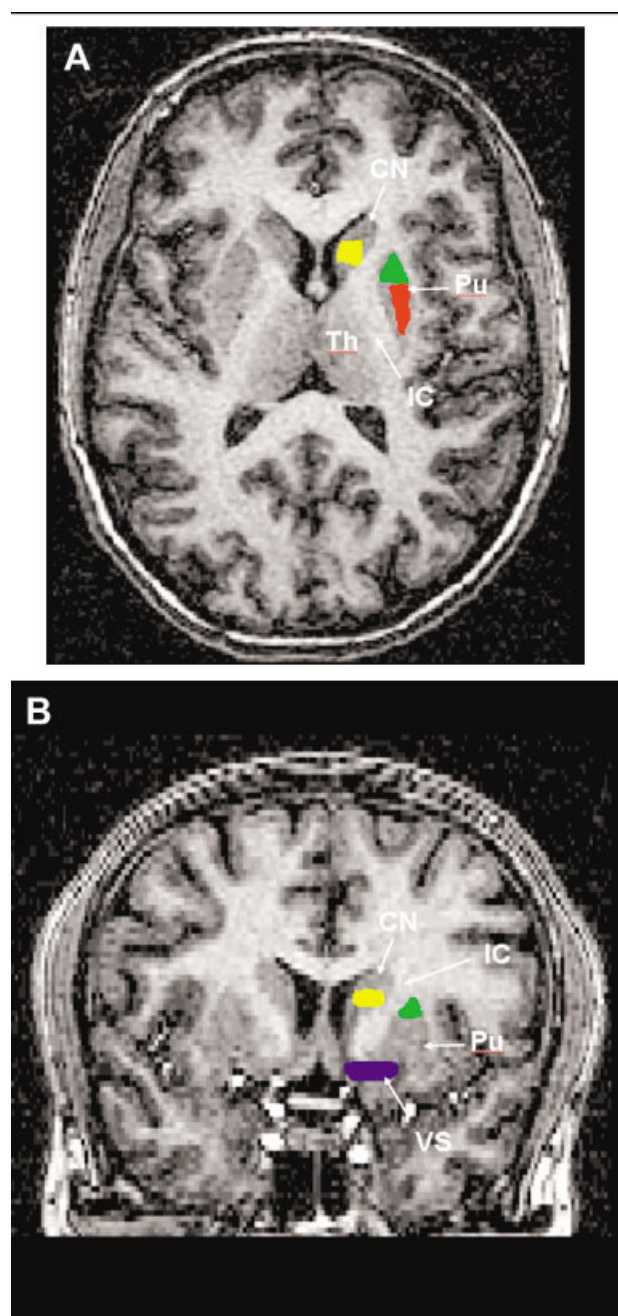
Location of the four regions of interest (ROIs). (A) Axial T1-weighted image passing at the level of the upper part of the putamen and (B) coronal T1-weighted image passing at the level of the rostral part of the striatum showing the location of the ROIs. The posterior putamen is represented in red, the anterior putamen in green, the caudate nucleus in yellow, and the ventral striatum in blue. Left is right. IC = internal capsule; CN = caudate nucleus; Pu = putamen; Th = thalamus; VS = ventral striatum.
